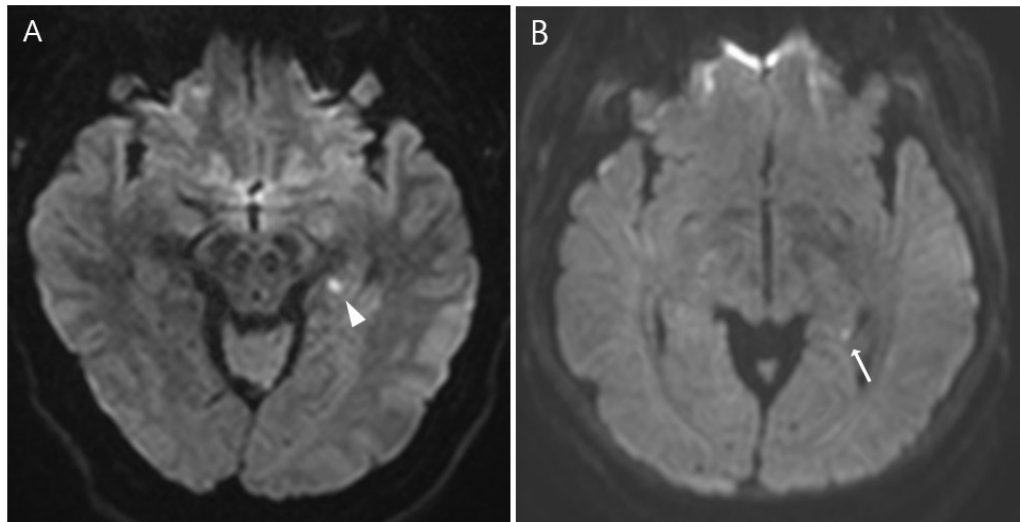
Magnetic resonance imaging findings. (A) Diffusion-weighted imaging shows punctate hyperintense signals in the left hippocampus, 4 hours after onset of symptoms (white arrowhead); (B) 2-years later, a new punctate restricted-diffusion lesion was revealed in the left posterior hippocampus
